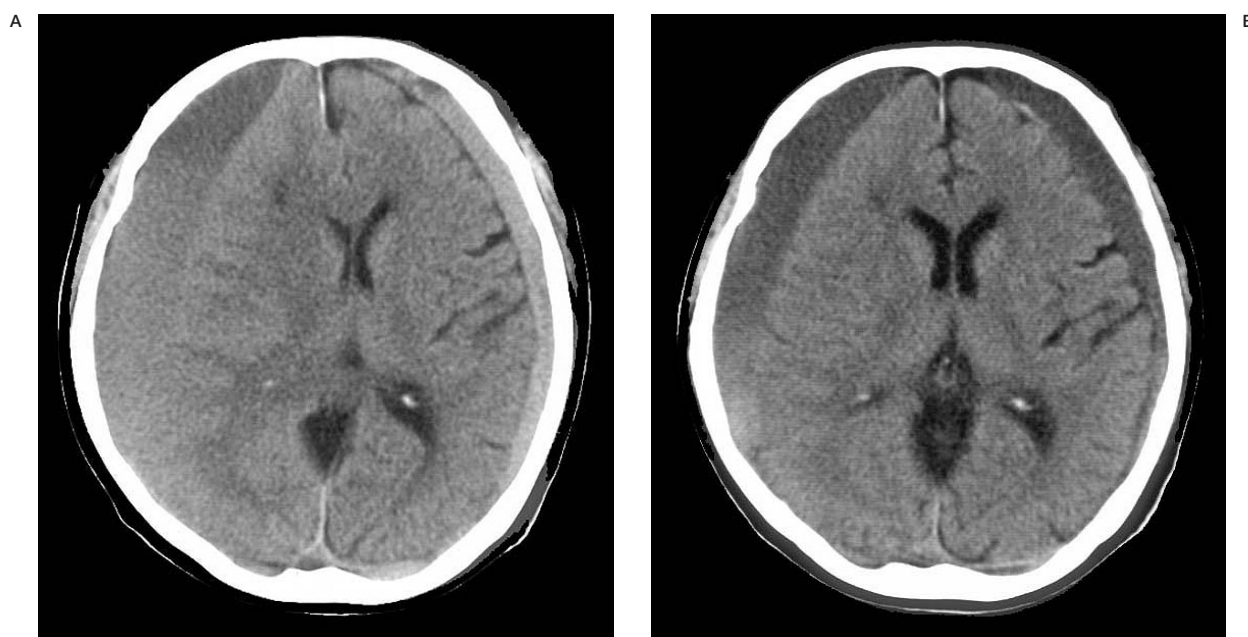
Preoperative (A) and postoperative (B) CT scans in Case 1. Bilateral subdural haematoma is noted even after the burr hole irrigation surgery.
